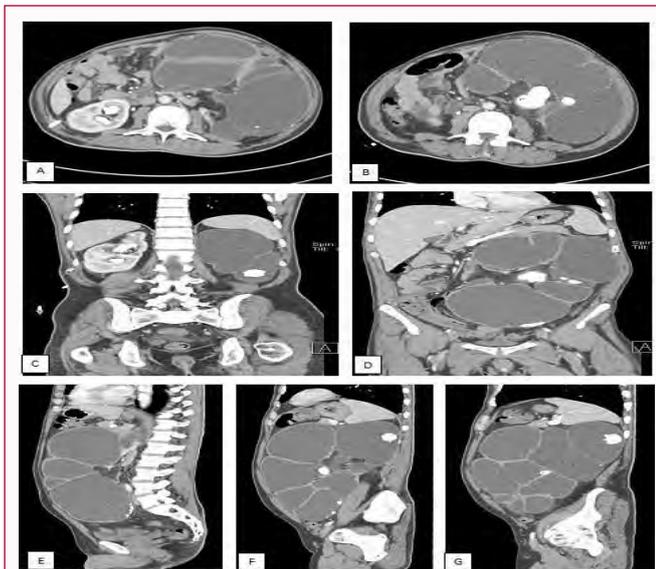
Multiple axial computed tomography after intravenous contrast injection, including sagittal (C-E) and coronal sections (F&G) showing multiple stones both kidneys. The left kidney measures 25-cm in CC dimension with severe cortical thinning and marked hydronephrosis.
